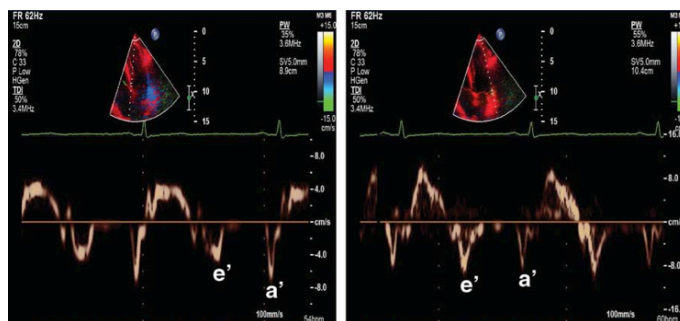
Mitral septal and lateral e' and a' waves from a patient's tissue-Doppler imaging (TDI)
